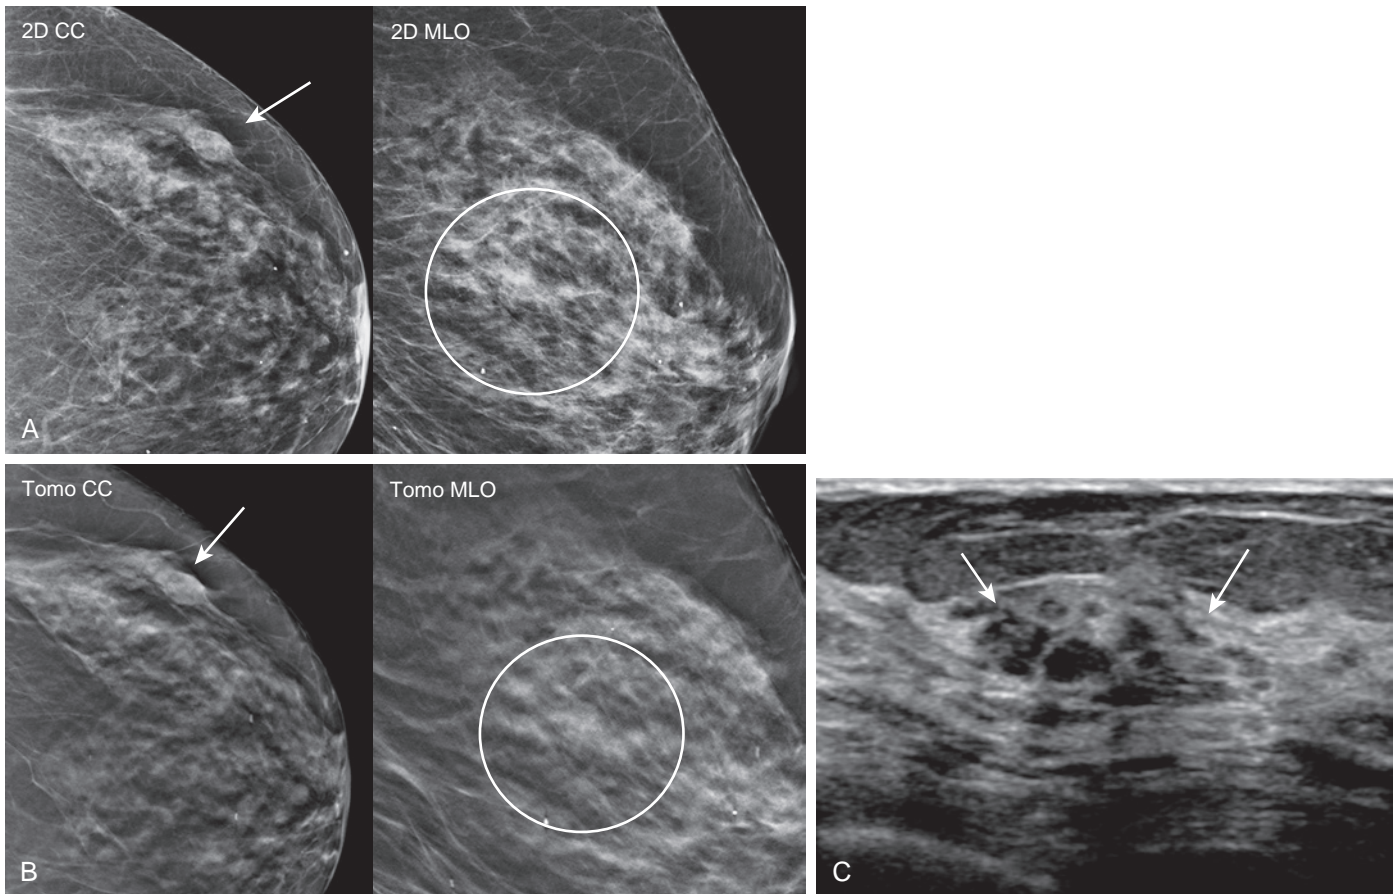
Circumscribed mucinous cancer. (A) Oval mass (*arrow*) in the left lateral breast seen best on the 2D CC view in an 80-year-old woman. Although not clearly identified on the MLO view, it is located centrally (*circle*). (B) Tomosynthesis demonstrates predominately circumscribed margins (*arrow*) on the CC view, best seen on a centrally located slice. The mass is located in the central breast on the MLO view (*circle*), although the margins are obscured even on tomosynthesis. (C) Targeted ultrasound reveals an oval, mixed echogenic complex mass with cystic components (*arrows*), BI-RADS 4B. Ultrasound-guided core needle biopsy yielded mucinous infiltrating ductal carcinoma, grade 1, ER/PR+, Her2–, 0/1 SLN.
